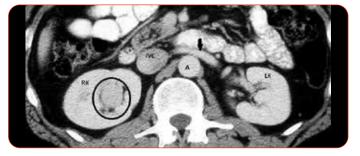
Enhanced axial CT scan showing solid tumour (black circle) in the right kidney (RK). IVC = inferior vena cava. A = aorta. LK = left kidney. Left renal vein (black arrow). Proven oncocytoma. (Courtesy of Professor PJ Pickhart, University of Wisconsin).
